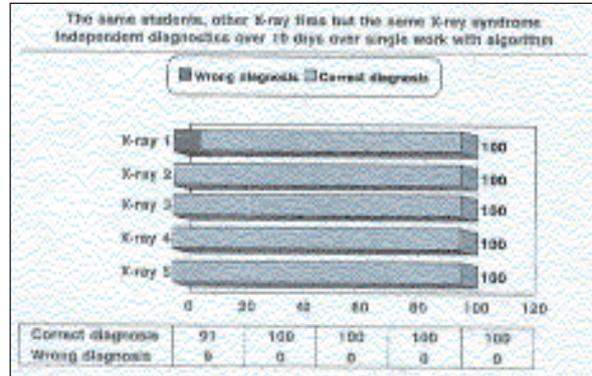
The second experiment, 10 days after. The same examinees, other 5 chest radiograms but with the same X-ray syndrome of total opacity. Independent diagnostics without the algorithm using, 110 diagnostic conclusions.
